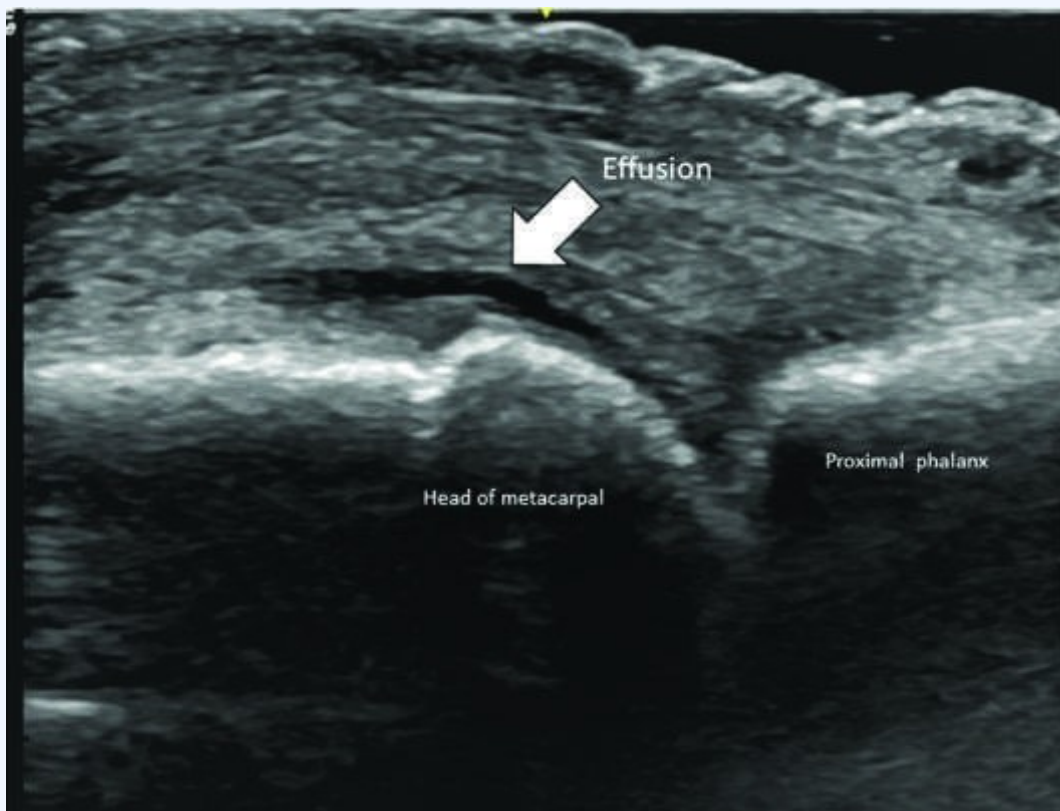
Ultrasound demonstrating an effusion (arrow) within the metacarpophalangeal joint. (Courtesy of Dr. Ryan Jessee.) — Global prevalence rates of rheumatoid arthritis (RA) with genetic associations and HLA-DRB1 alleles.
